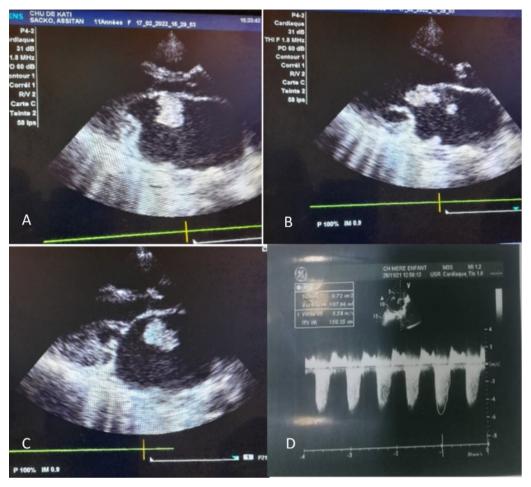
Transthoracic ultrasound, long axis parasternal. Mass attached to the large mitral valve ((A), (B), (C)). Mitral regurgitation grade III (D).
